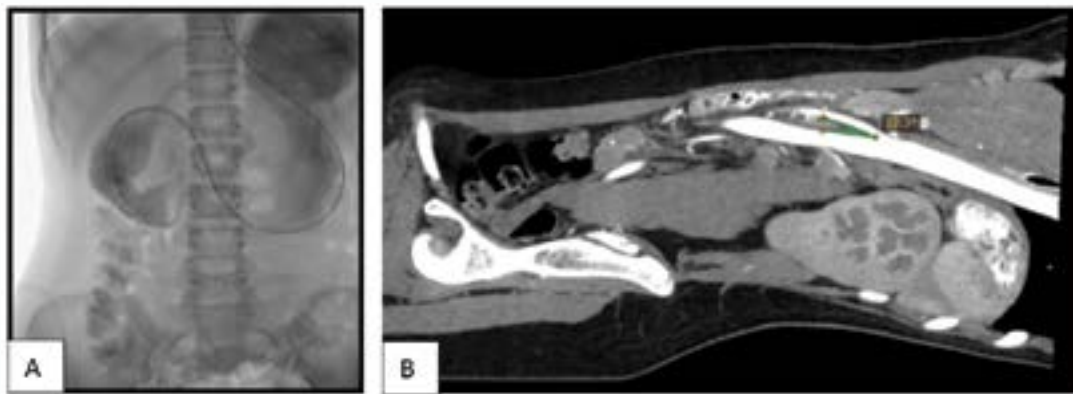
(A). Upper gastrointestinal fluoroscopy. (B). Abdominal CT scan Longitudinal Slice.
